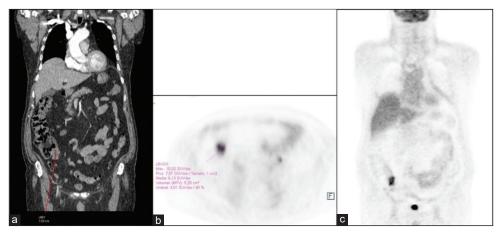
(a) Whole-body computed tomography (CT) scan showing mural thickening at an ileal segment (red line). (b and c) PET-CT scan showing a significant uptake at the same engrossed segment founded in CT scan. (F): Frontal.
